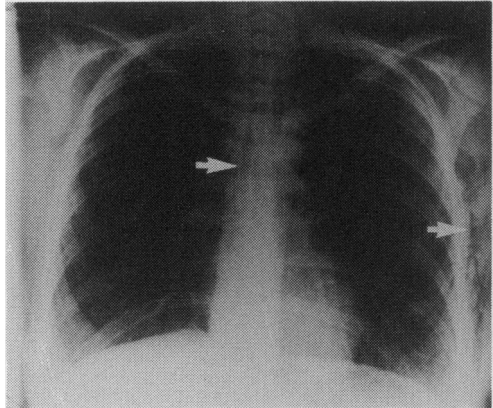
Chest X-ray demonstrating subcutaneous and mediastinal emphysema due to oesophageal rupture.
